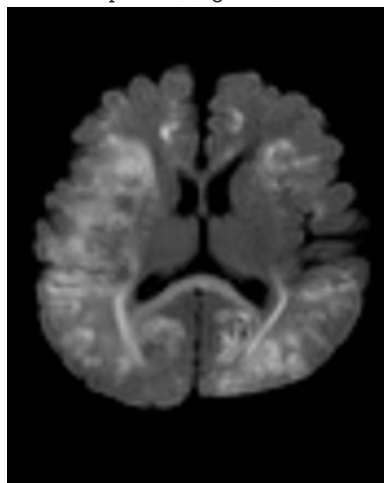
Axial diffusion weighted magnetic resonance imaging sequence showing diffusion restriction in bilateral fronto-parietal region and splenium of corpus callosum
